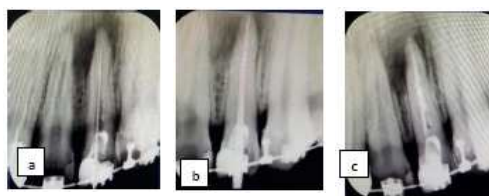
Radiographic photo of tooth 22 (a) master file #20. (b) main guttap (c) calcium hydroxide medication
